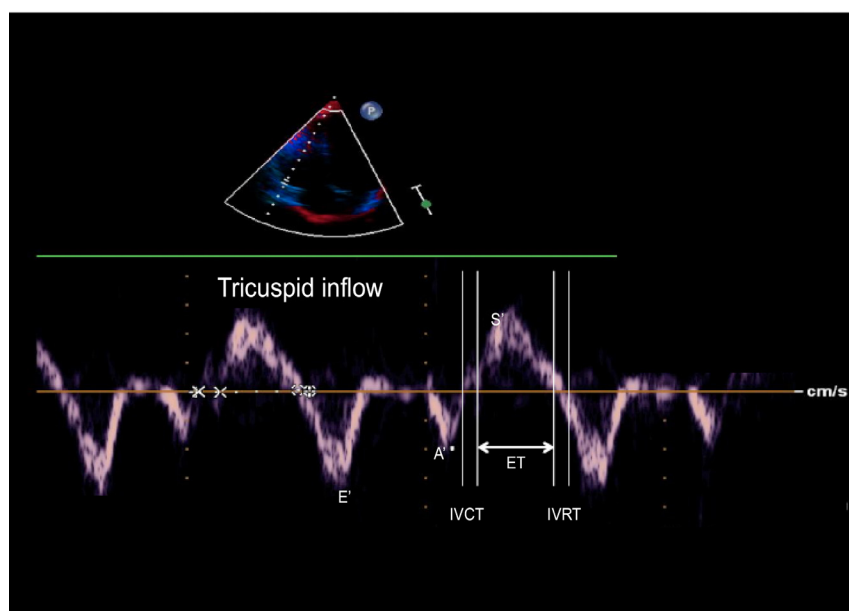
Tissue Doppler imaging performed at tricuspid annulus in apical 4-chamber view (E': peak early diastolic annular tricuspid velocity; A': peak late diastolic annular tricuspid velocity; S': systolic annular velocity; IVRT: isovolumetric relaxation time; IVCT: isovolumetric contraction time; ET: ejection time)
